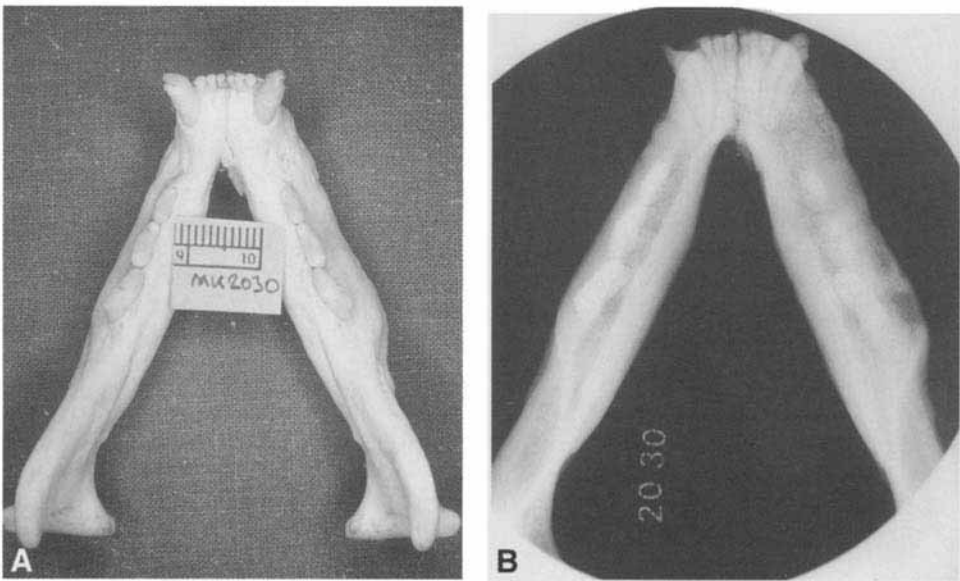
(A) Bilateral severe mandibular thickening with complicated crown-root fractures of both CmandL, but no evidence of periapical lesions. (B) Occlusal radiograph of the same case; note the apparent density of the mandibular bone.
